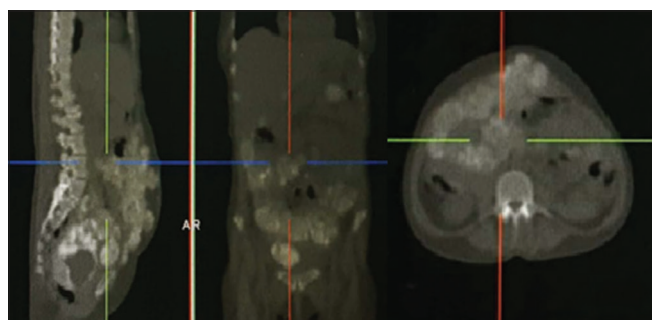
Computed tomography bone window images in sagittal, coronal and transverse planes showing abdominopelvic calcifications
